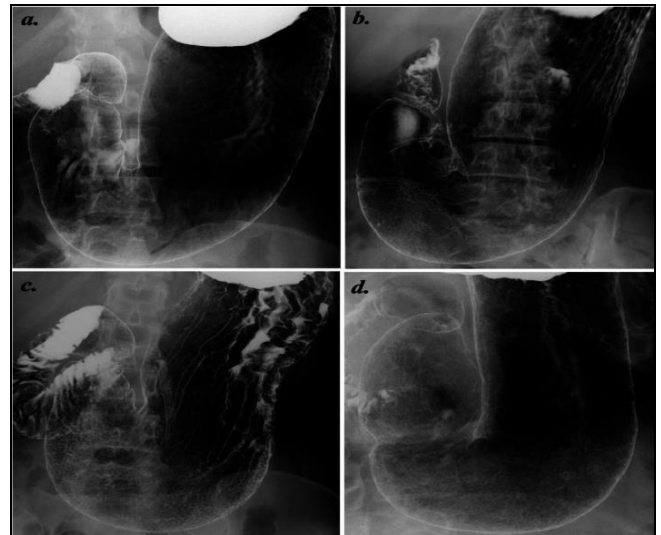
Contrast radiographic of GIT
